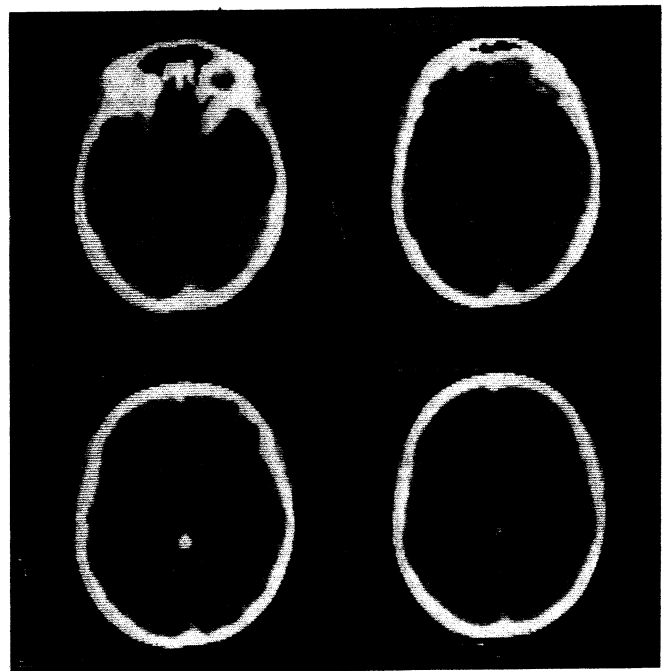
Case 2, post-irradiation CT scan with enhancement: The pineal calcification is unchanged but the tumour size is reduced considerably. The lesions within the frontal horns and the suprasellar cisterns have vanished.
